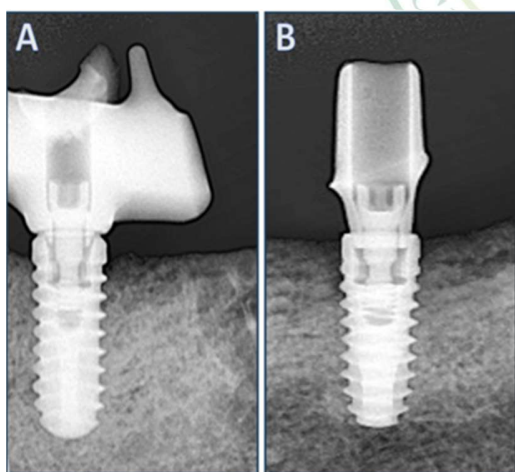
Marginal bone loss evaluation via digital periapical radiographs of titanium (A) and PEEK (B) bars.
